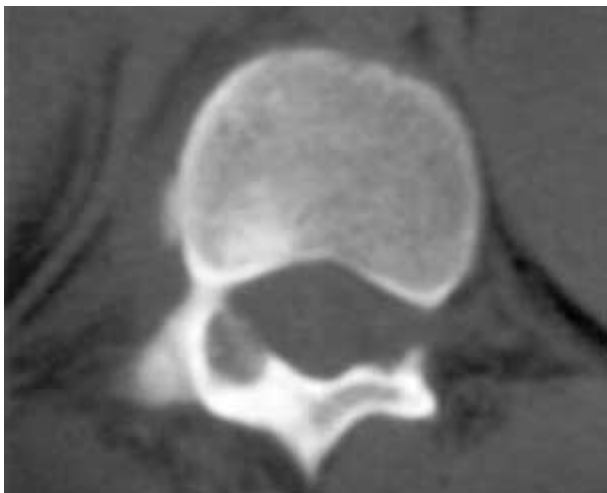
CT scan of Case 4 showing the nidus in the right pedicle.
